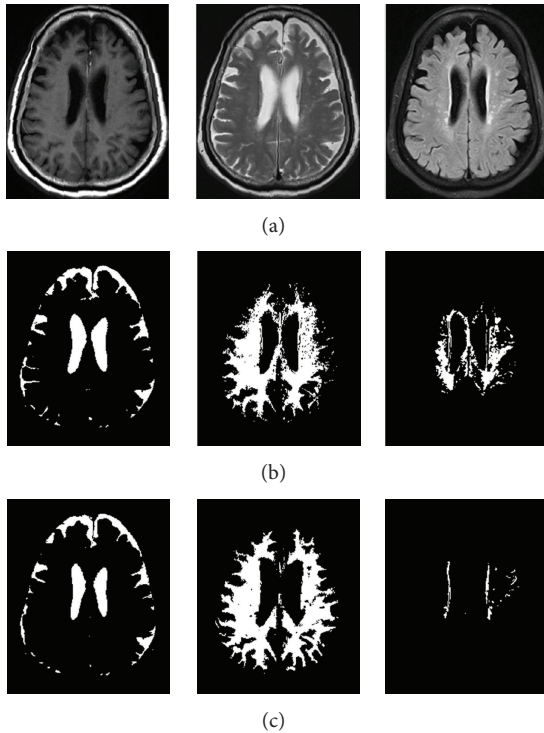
FCM Classification results in the order of CSF, WM and WML from left to right. (a) Clinical input images, T1WI, T2WI and FLAIR from left to right. (b) ICA based results. (c) MW-ICA based results.
